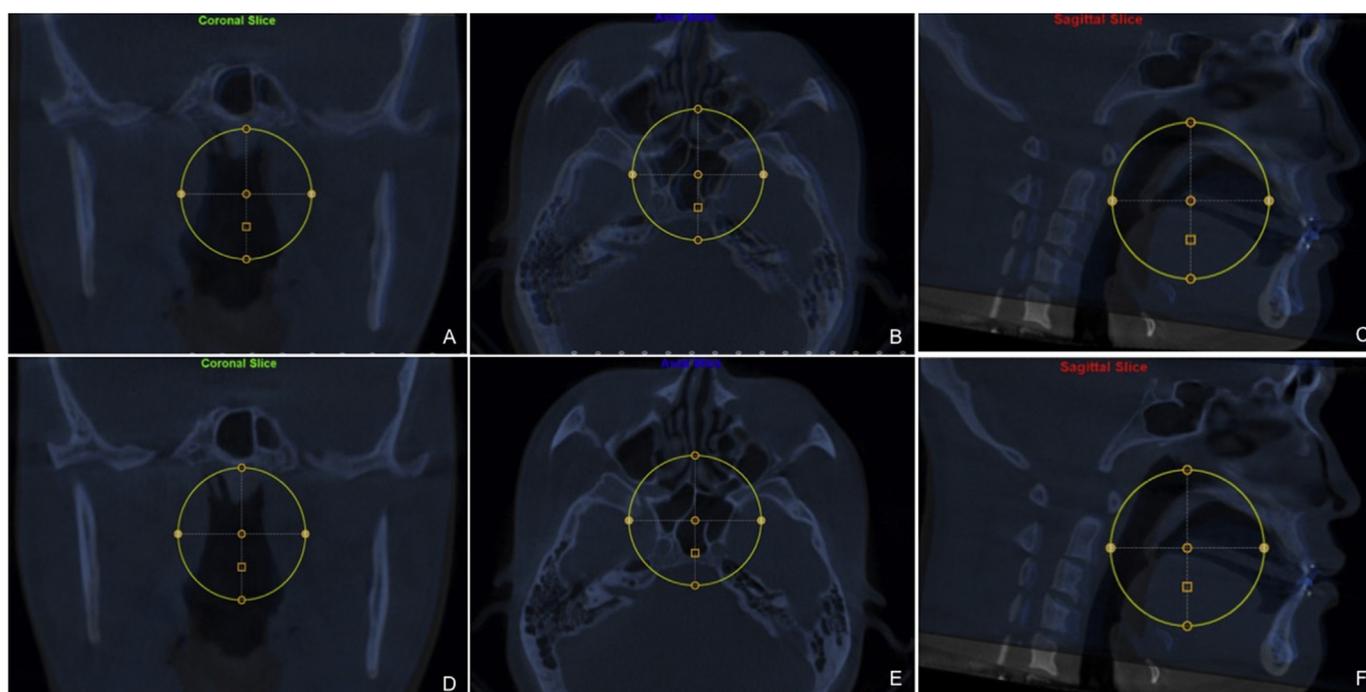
Superimposed of pre-operative (in gray) and post-operative (in blue) CBCTs before the fine adjustments. (A): Coronal slice, (B): Axial slice, (C): Sagittal slice and after the fine adjustments, (D): Coronal slice, (E): Axial slice and (F): Sagittal slice.
